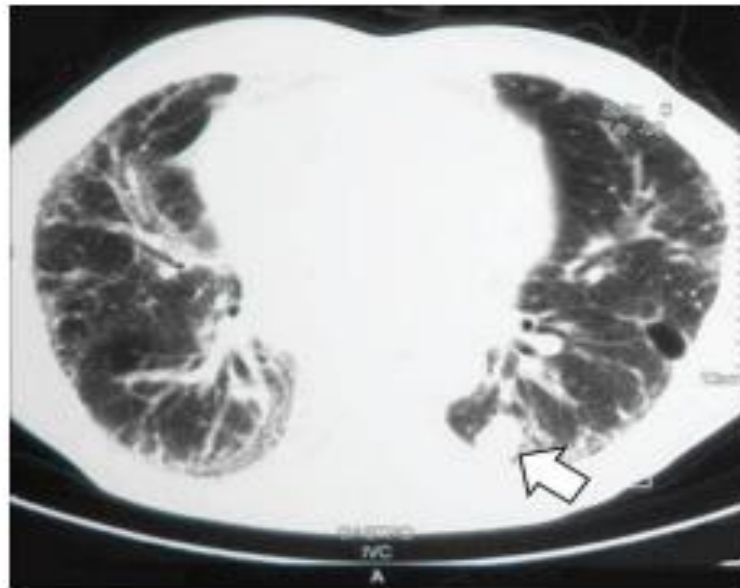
CT scan of a 72-years-old male with IPF and adenocarcinoma.
